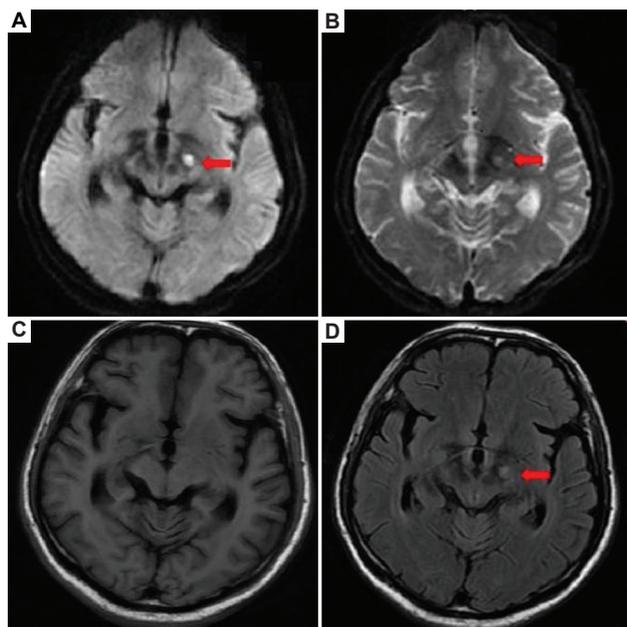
Magnetic resonance imaging indicating a discrete lacunar infarction in the left substantia nigra (SN). (A) Diffusion-weighted imaging (DWI) showing a new infarct in the SN of the left cerebrum. (B) An image of DWI sequence (b0), which is similar to a fast-scan T2WI sequence. (C) No abnormal signals in T1-weighted image. (D) T2-weighted image/fluid-attenuated inversion-recovery (FLAIR) showing a high-signal lesion located in the left SN.
